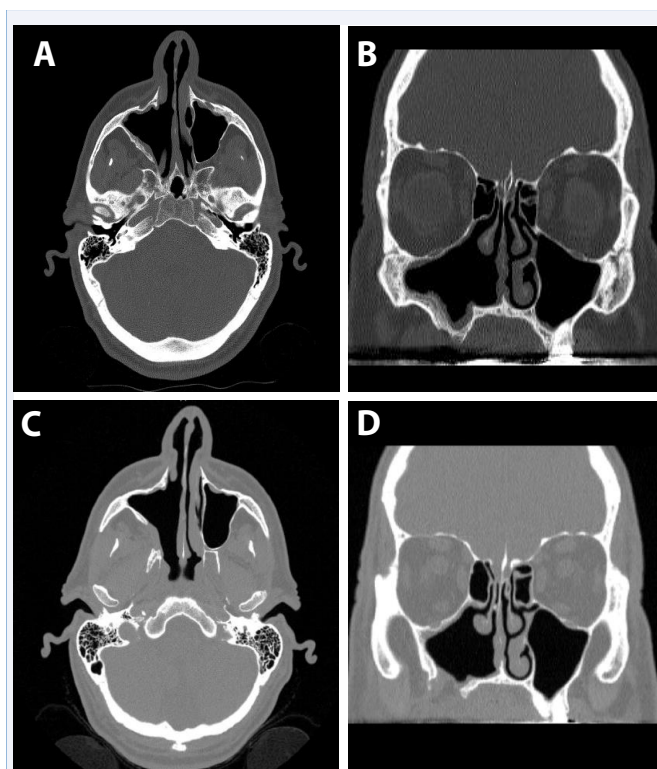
Case 3 (A) Axial view and (B) Coronal view; post-operative CT images at 3 months; no tumor residue or recurrence noted. (C) Axial view and (D) Coronal view; post-operative CT images at 12 months show no recurrence.
